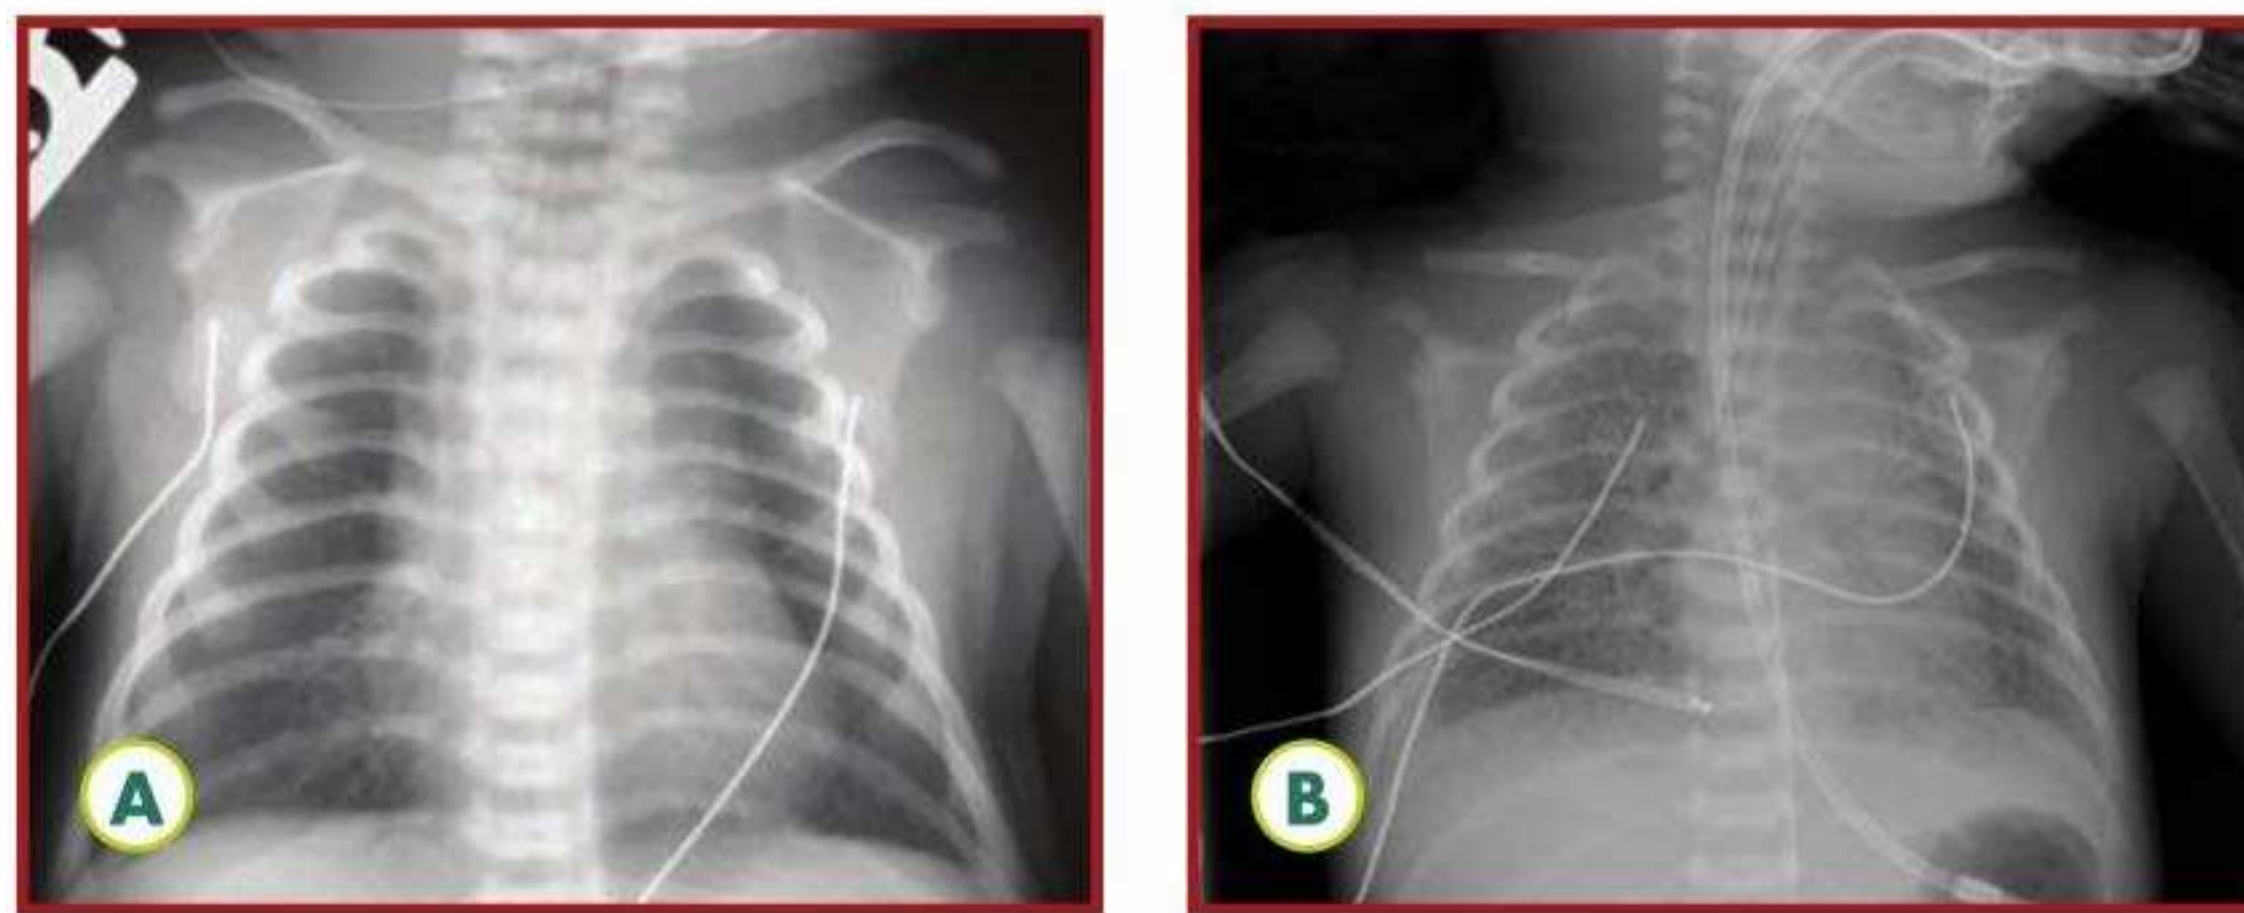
Neonatal chest x-rays: (A) normal, (B) pneumonia
